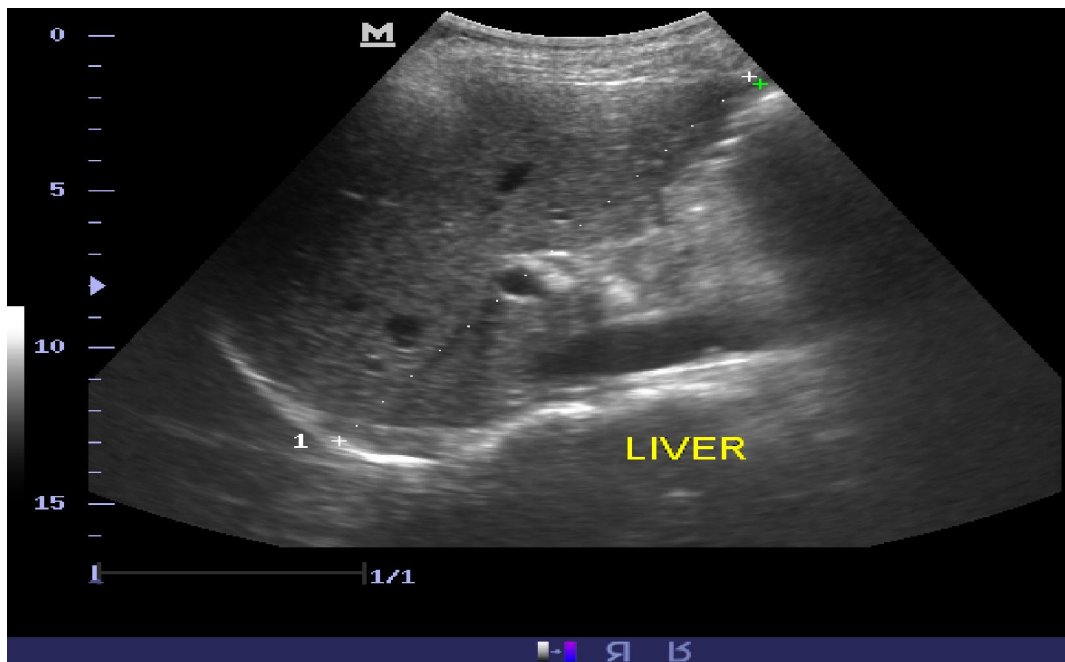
sonographic measurement of liver span in MCL.
